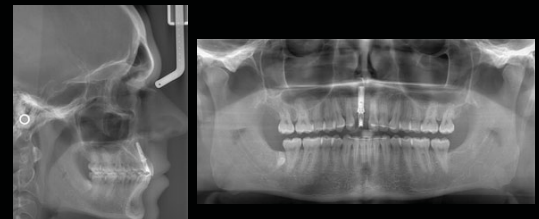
Post orthodontic treatment and implant placement profile tele-radiography and orthopantomography
